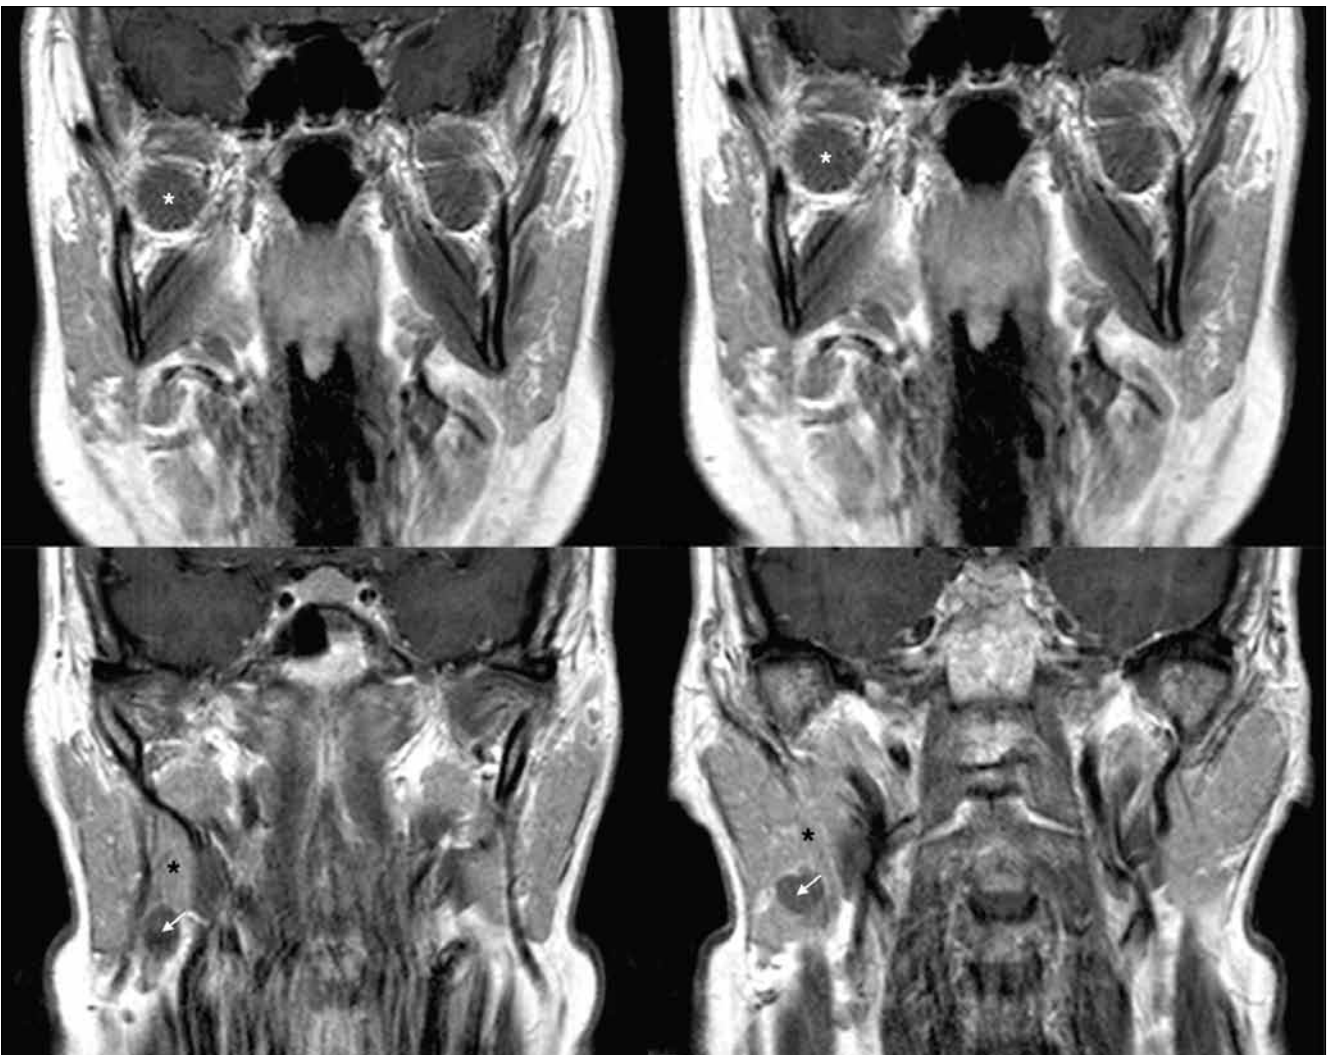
Four consecutive coronal preoperative MRI scans in a TCA; the images show the presence of healthy salivary tissue (black asterisk) between the tumour (white arrow) and the LPM (white asterisk).
